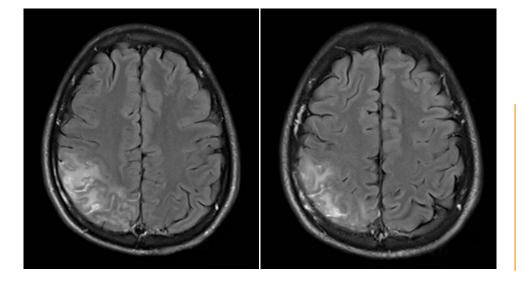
Magnetic resonance imaging of the brain (June 2023) showing right parietal essentially cortical gyriform pattern lesions with spotty nodular and curvilinear enhancement as well as adjacent focal leptomeningeal enhancement (pine tree pattern), with element of subcortical oedema.
